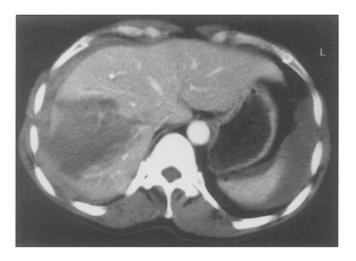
CT scan demonstrating a laceration and large intraparenchymal haematoma.
